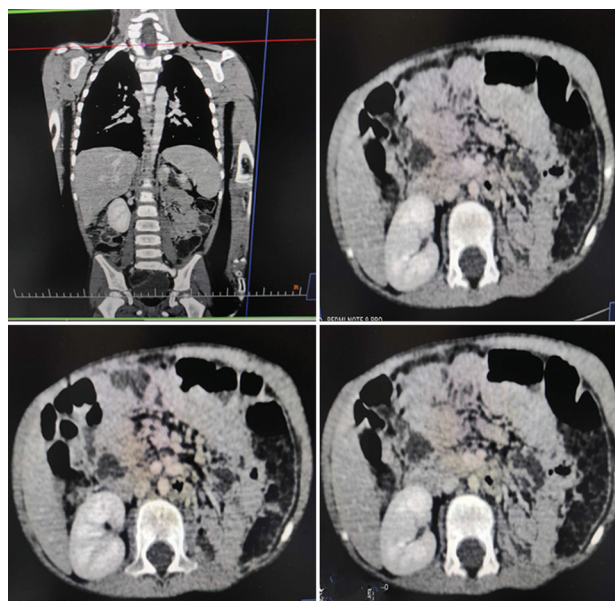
Computed tomography imaging prior to left nephrectomy
